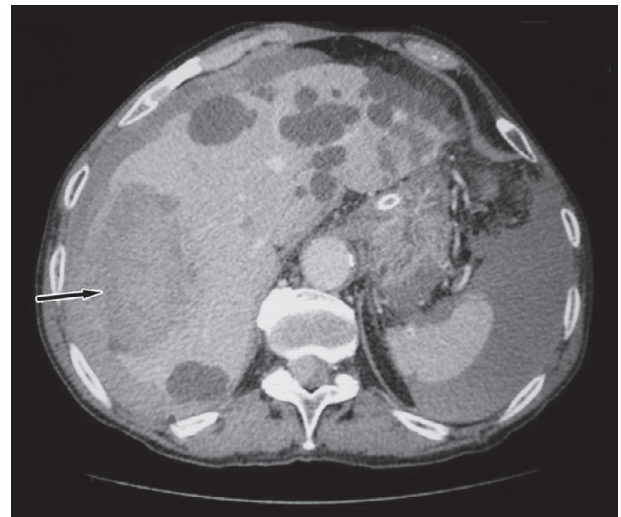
Emergency CT scan performed on admittance. A huge, clearly visible ruptured hemangioma positioned in the right lobe of the liver (arrow). Also visible leakage and blood accumulation surrounding the liver indicating hemoperitoneum. Multiple cysts present in the remaining hepatic parenchyma.
